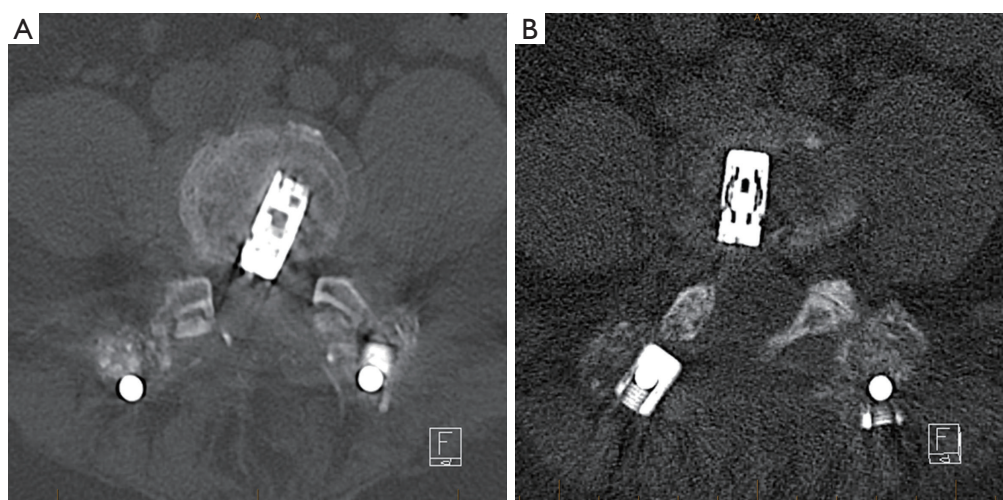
A 72-year-old male suffered an early fall forwards causing L4/5 cage retropulsion: (A) axial CT 2 weeks post-operative; (B) axial CT showing cage removal then repositioning. CT, computed tomography.
